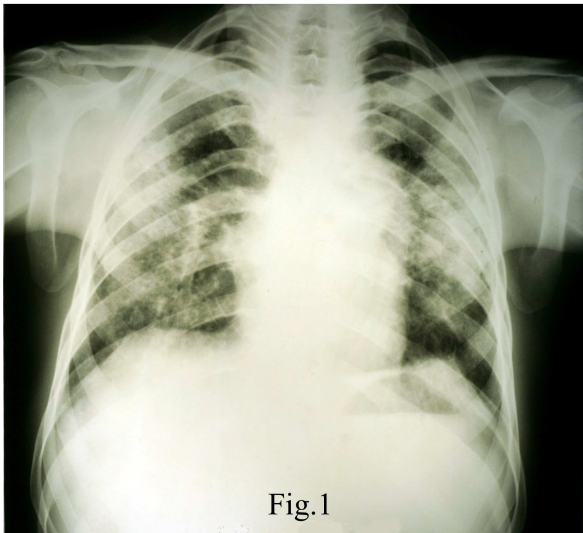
Chest x-ray of the patient showing 1) shaggy heart, 2) diaphragmatic tenting in both diaphragms, 3) blunting of left and right costophrenic angles and pleural thickening, 4) mixed alveolar and interstitial shadowing in both middle lobes and apical segments of both lower lobes, 5) airbronchogram pattern and peribronchial thickening, 6) prominent hilar areas, and, 7) alveolar shadowing in the left upper lobe.
